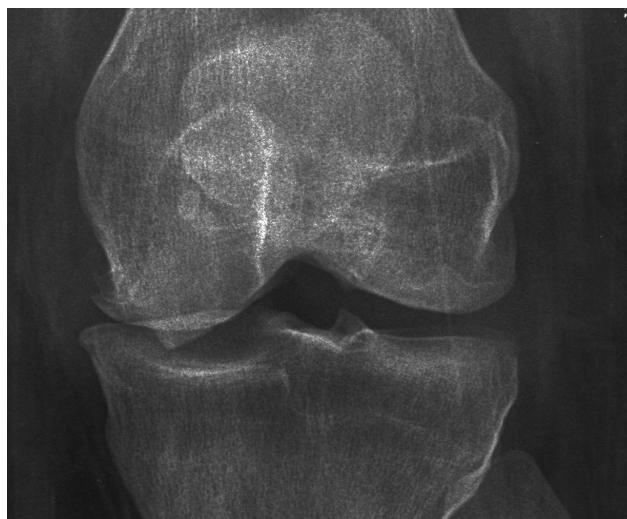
Preoperative anteroposterior radiograph of left knee shows bony irregularity at distal medial femoral condyle.
